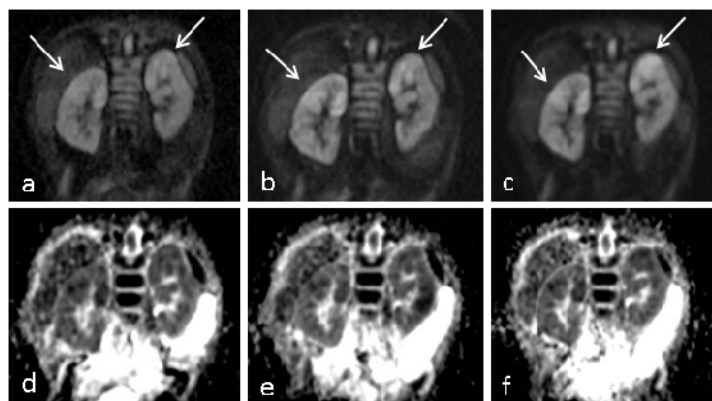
Diffusion weighted images of an infant with bilateral pyelonephritic lesions (arrows). Coronar DWI with b=700 s/mm² (a-c) and ADC maps (d-f) acquired with cDWI (a,d), tDWI (b,e) and DTI (c,f) sequences. The high signal pyelonephritic lesion areas with corresponding low ADC areas are best visualized in DTI (c,f) that is less noise vitiated compared to cDWI and tDWI images.
